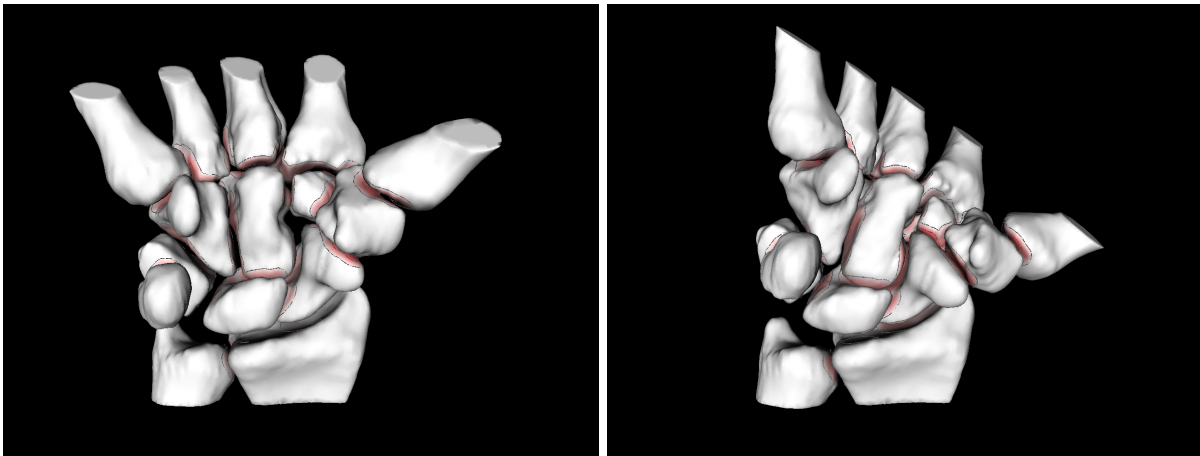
Modeling inter-bone joint-spacing with motion: two different poses recovered through CT-imaging, segmentation and registration of the same wrist joint (eight carpal, two forearm, and five metacarpal bones). Bones are color-mapped and contoured. The color saturation on bone surfaces indicates the distance to the nearest point on the opposite bone; darker regions are closer. Bone surfaces where the inter-bone distances are larger than a prescribed threshold (2mm) are shown in white. We trace these minimum-distance regions across multiple poses in order to estimate cartilage-map location and thickness.
